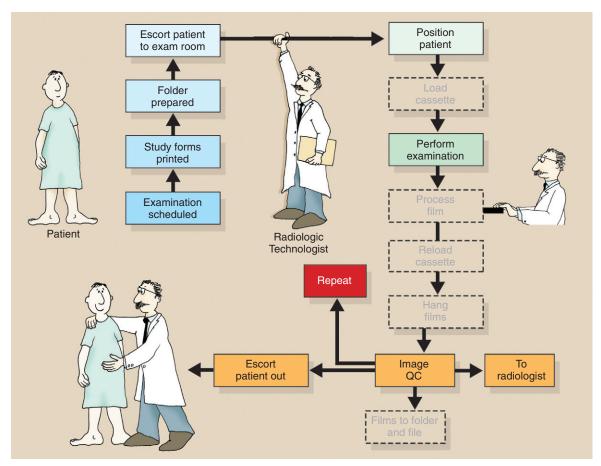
Several additional steps are eliminated when progressing from screen-film radiography through CR to DR.
